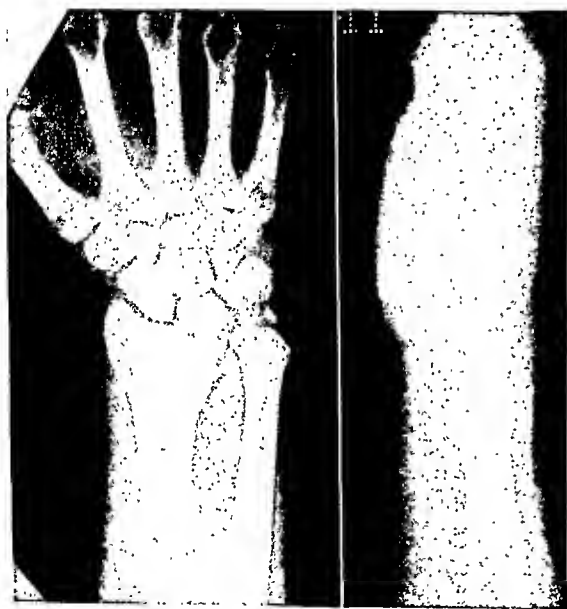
C, W. C., sixteen months postreduction; the subjective and objective results are good but the roentgenographic result is only fair. Kirschner wires of small diameter bowed in the cast after reduction and allowed moderate recurrence of radial shortening.
